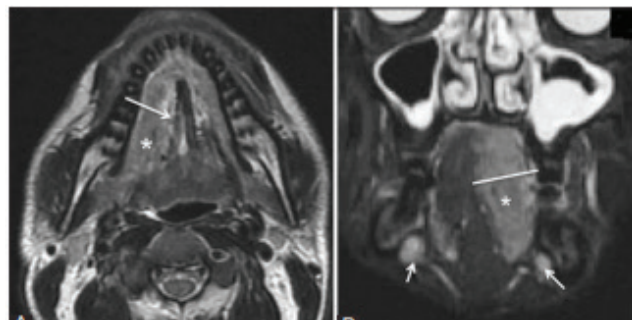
Image of Magnetic resonance imaging of head
